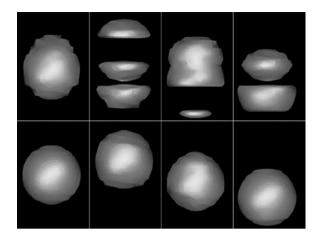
Isosurface renderings of a spherical object (radius 1.2 cm), CT scanned while periodically moving on a sliding table (amplitude 1 cm, period 4.4 s). *Top row*: different artifacts obtained by standard axial CT scanning. Artifacts depend on the interplay (relative motion phase) between CT data acquisition and object motion; to measure different artifacts, CT scans were started at different motion phases. Note that slices of the object can be imaged in mixed order. *Top row, right image* shows two disconnected parts of the sphere, the upper part consists of the top and the bottom of the sphere. *Bottom row, left*: a CT scan of the static object. Other images show three positions of the sphere while moving as imaged with 4D-CT (29 images per couch position reconstructed). Only small residual artifacts on the surface remain, the object is imaged at different positions of the motion cycle. Reprinted from [17] with kind permission from AAPM
